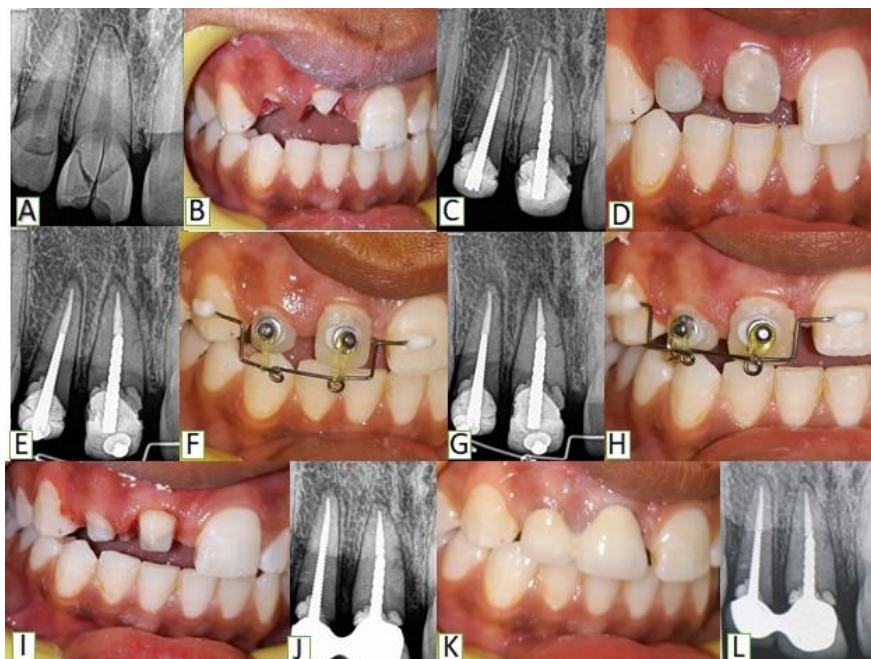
Case Report 1: (A)Pre-operative radiograph with complicated crown fracture. (B) Pre-operative clinical picture after segment removal. (C)Radiograph after post cementation and core buildup. (D)Clinical picture after post cementation and core build up. (E, F) Orthodontic extrusion after 1 month. (G, H) Final orthodontic extrusion at 2 months. (I) Crown cutting. (J) Post-operativepicture. (K) Follow up at 12 months.
